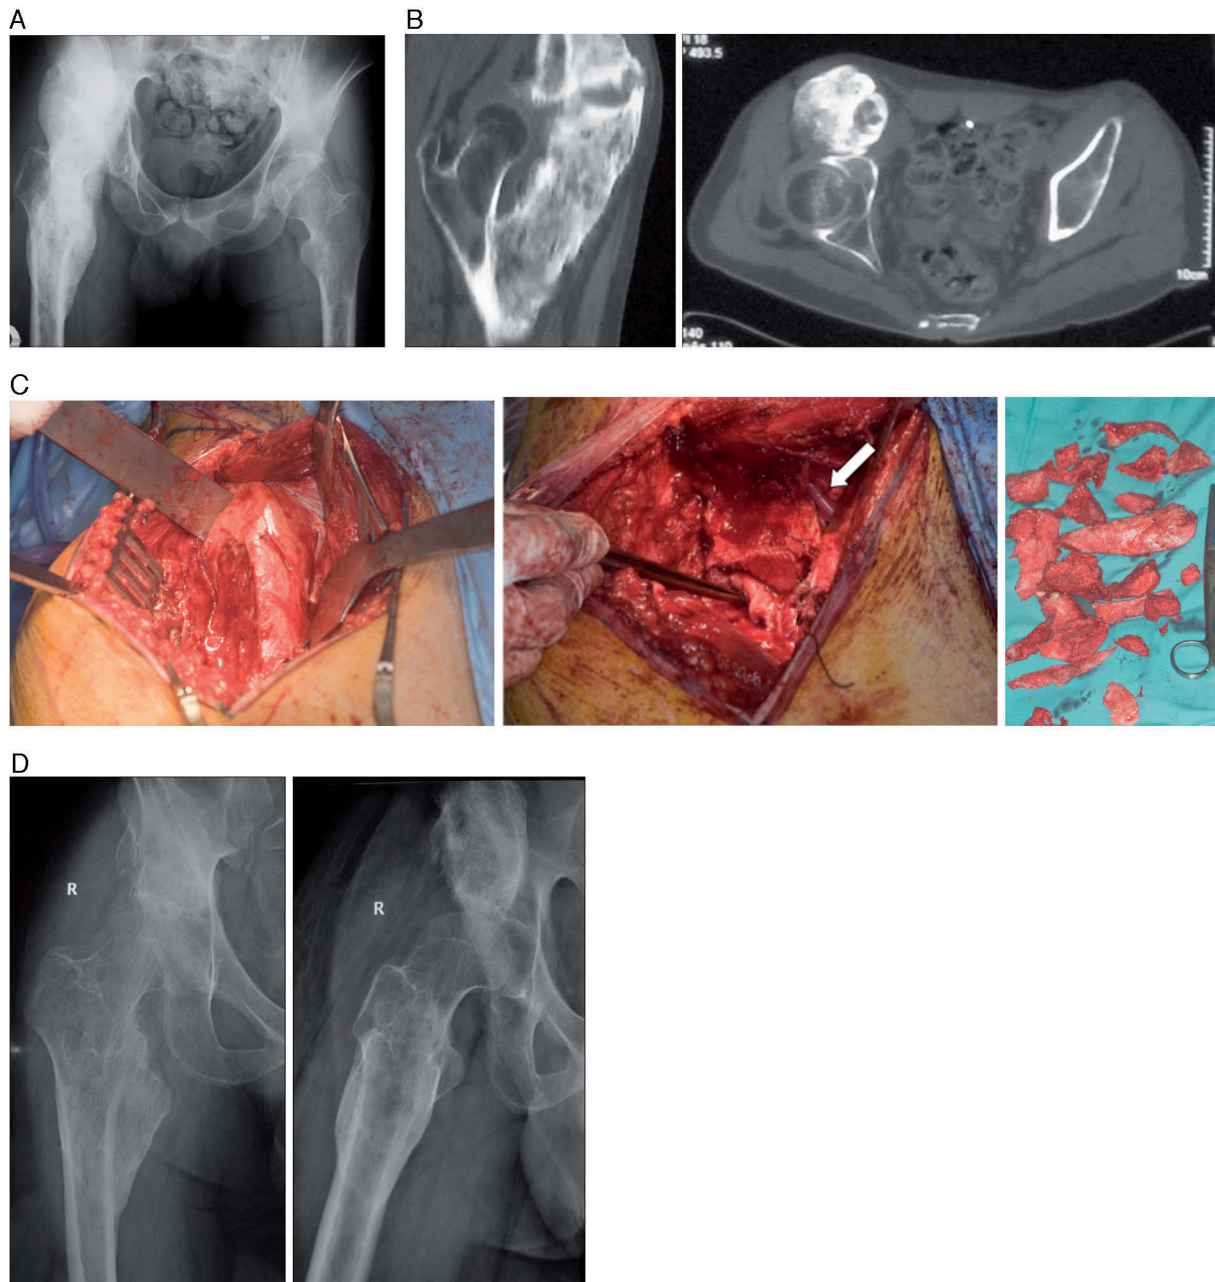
Images for case 2. A) X-ray of right hip at 12 months after the CVA. B) CT showing ossification involving the psoas, vastus intermedius and medialis. C) Images from the surgical procedure (left to right): exposure of the ossification via a Smith-Petersen approach; after most of the lesion was resected, its proximity to the deep femoral artery (arrow) was appreciated as well as the fact that it extended to the plane of the joint capsule (held by dissecting forceps); bony fragments removed. D) Anteroposterior and axial x-rays at 12 months after the surgery.
